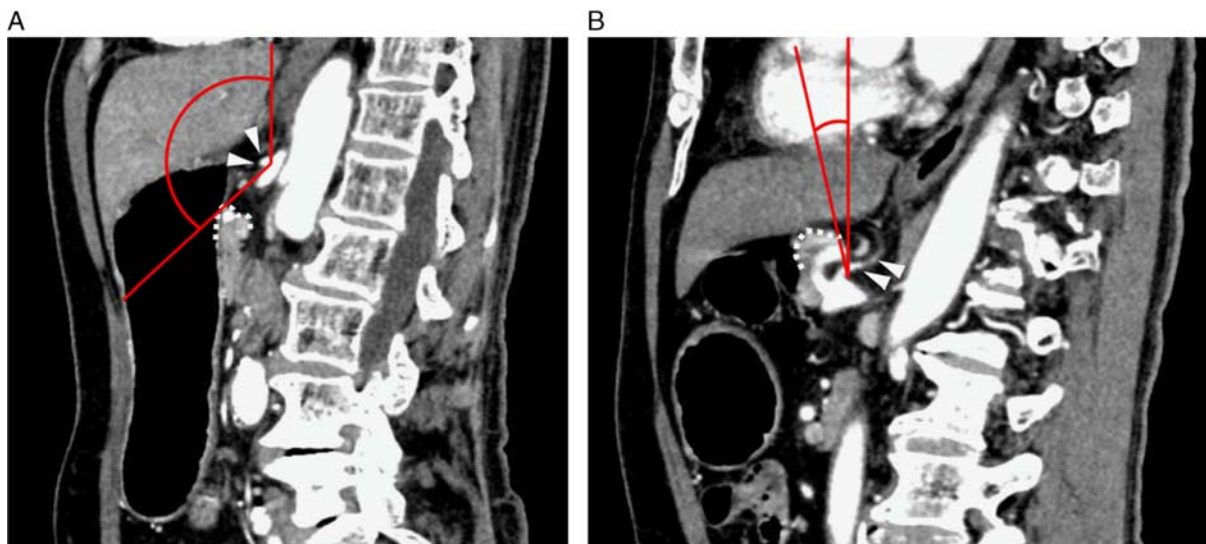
The pancreas-left gastric artery angle (indicated by the red lines) was defined as the angle between horizontal and a straight line connecting the upper edge of the pancreas (white dotted lines) and the root of the laparoscopic distal gastrectomy (white arrowheads) in a preoperative abdominal contrast-enhanced computed tomography image with sagittal section. A, An example from a patient with a large pancreas-left gastric artery angle = 135.6 degrees. B, An example from a patient with a small pancreas-left gastric artery angle = 4.1 degrees.
